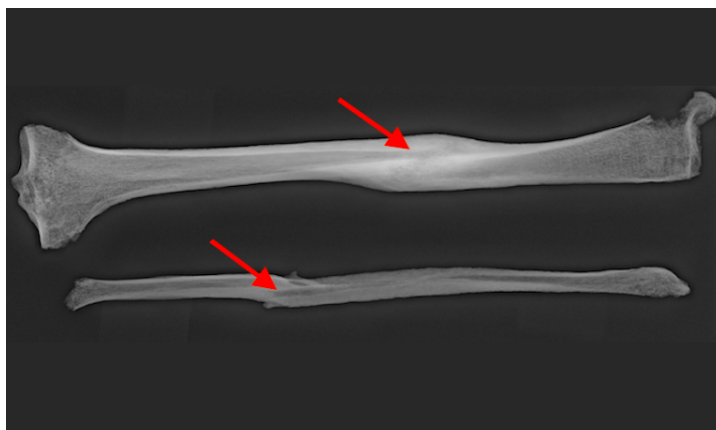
Nr.10, InvNr 27902 Grave ID 238: healed fractures of the left tibia and fibula. The red arrows present the visible fracture lines on the x-ray image (photographed by A.Wagner)
